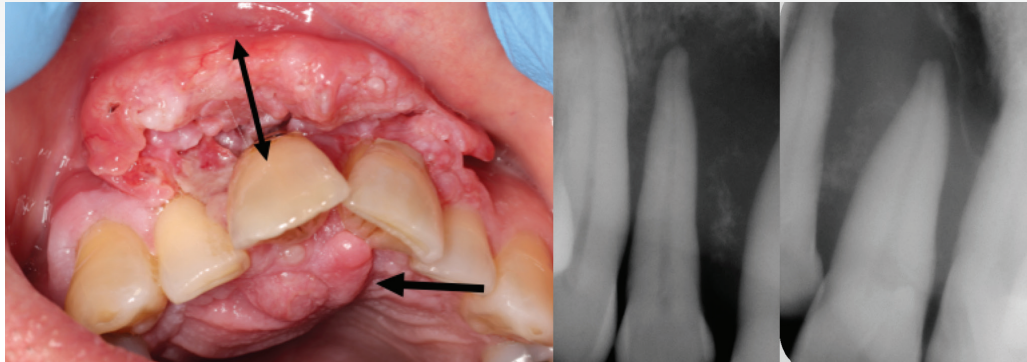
The gingiva is enlarged and loose from underlying teeth with a wartlike appearance. Tissue enlargement is also visible on palatal side. Radiographs sent by dentist shows complete destruction of all bone around teeth 12-21.
